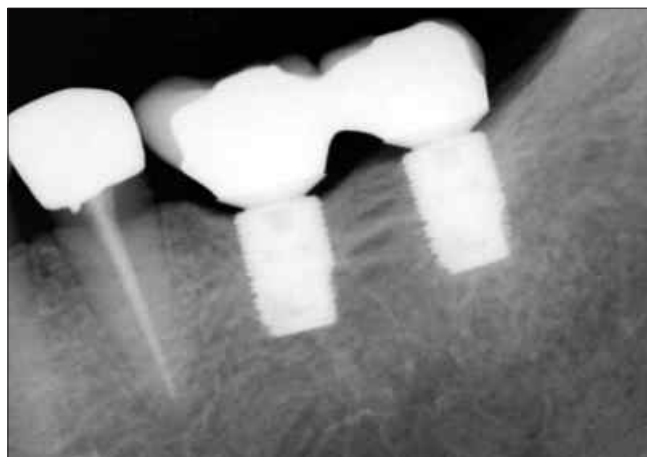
Periapical radiograph 25 months after prosthetic loading. The crestal bone level has been maintained.
